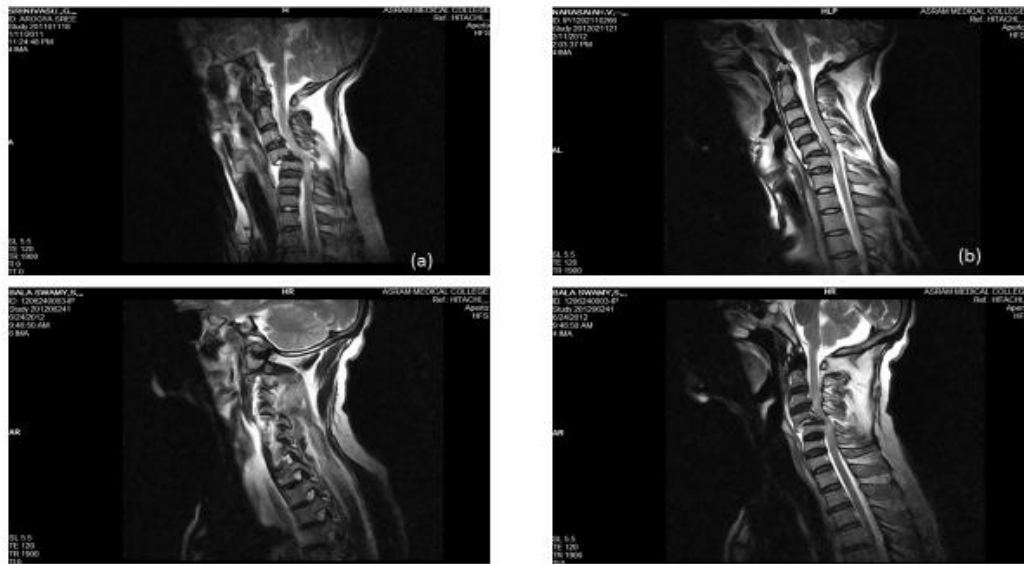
(a)-T2-weighted sagittal image of C-spine showing subluxation of C4 over C5 and disruption of anterior longitudinal ligament.
